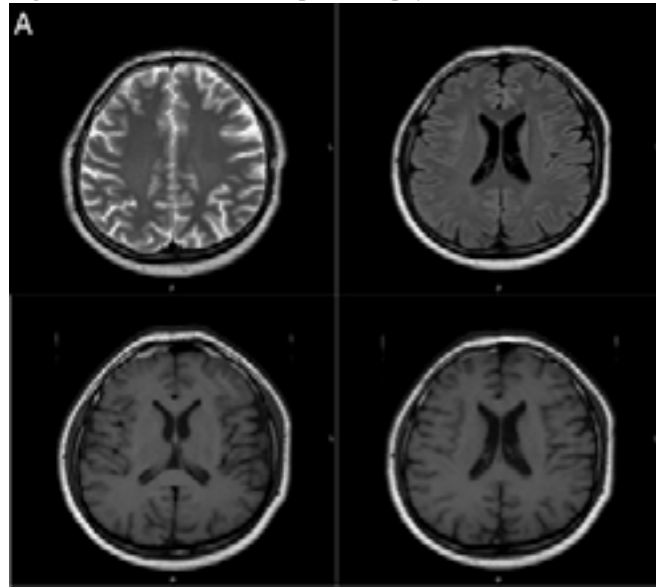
MRI shows left temporal atrophy
